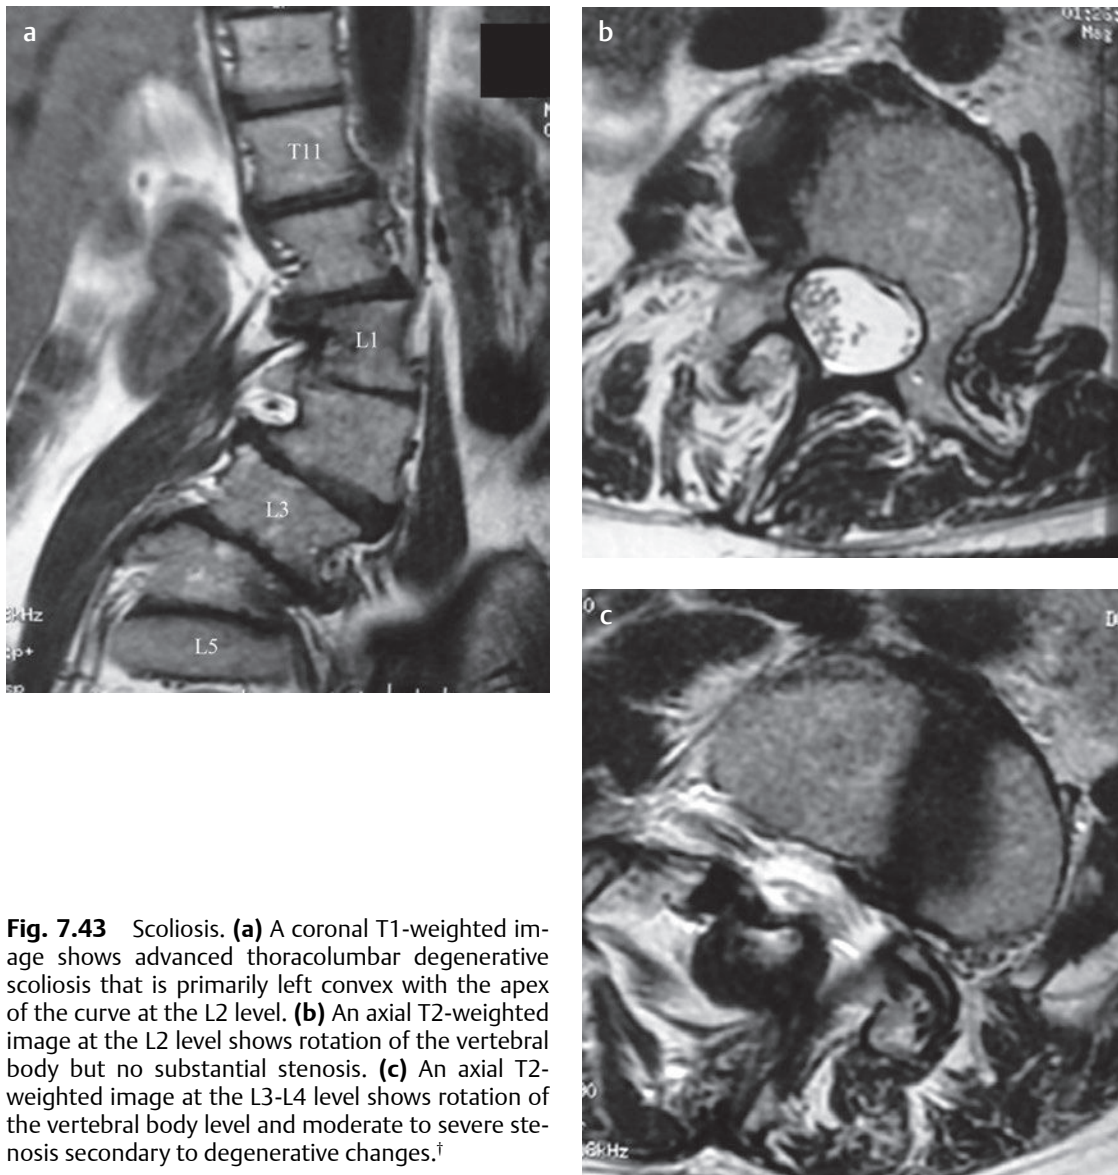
Scoliosis. (a) A coronal T1-weighted image shows advanced thoracolumbar degenerative scoliosis that is primarily left convex with the apex of the curve at the L2 level. (b) An axial T2-weighted image at the L2 level shows rotation of the vertebral body but no substantial stenosis. (c) An axial T2-weighted image at the L3-L4 level shows rotation of the vertebral body level and moderate to severe stenosis secondary to degenerative changes.[†]
